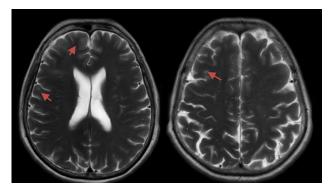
T2-weighted brain magnetic resonance imaging (PROPELLER) shows hyperintense lesions with diffuse limits in the subcortical región of the right frontal lobe suggestive of tubers; at periventricular level white matter, hyperintense lines are observed bilaterally that extend towards the cortex and correspond to lines of radial migration.
